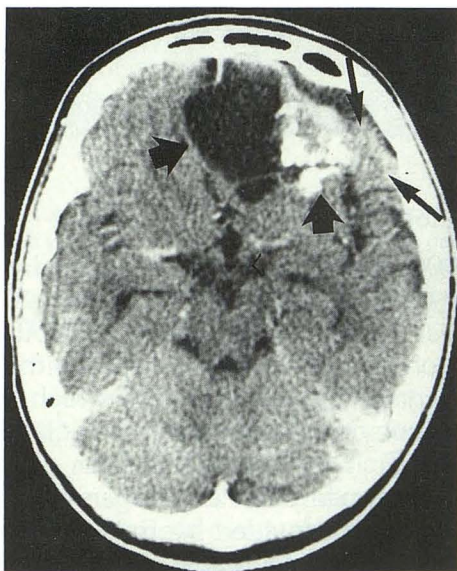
Fifteen-year-old girl with focal seizures. Contrast-enhanced CT demonstrates a bifrontal well-defined low-density and calcified mass (*block arrows*). There is minimal enhancement (*long arrows*).
